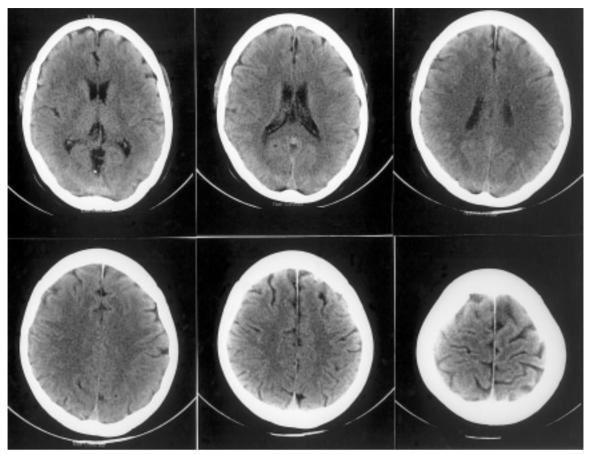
CT scan of brain without contrast enhancement 2 months after Chinese herbal therapy shows the right fronto-parietal chronic subdural hematoma has disappeared, and the brain swelling subsided without midline shift.
